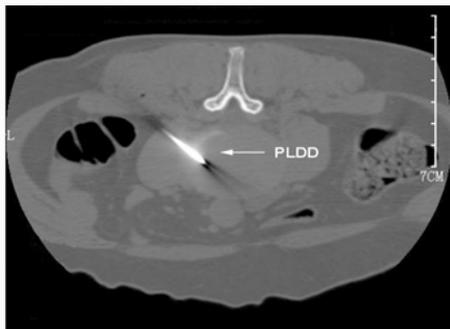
Intraoperative CT images of PLDD.
